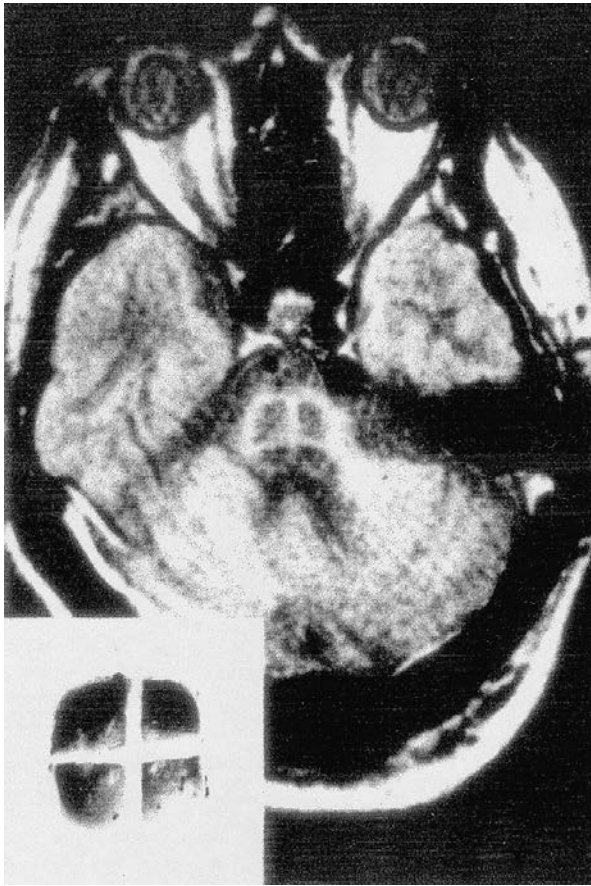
MRI T₂-weighted image of the brainstem in a patient with multiple system atrophy showing infratentorial atrophy and typical signal change in the pons in the form of a cross resembling that seen on hotcross buns (inset) which are baked typically over Easter. (Courtesy Prof. Niall Quinn, Institute of Neurology, Queen Square, with permission from Journal of Neurology, Neurosurgery and Psychiatry.)
